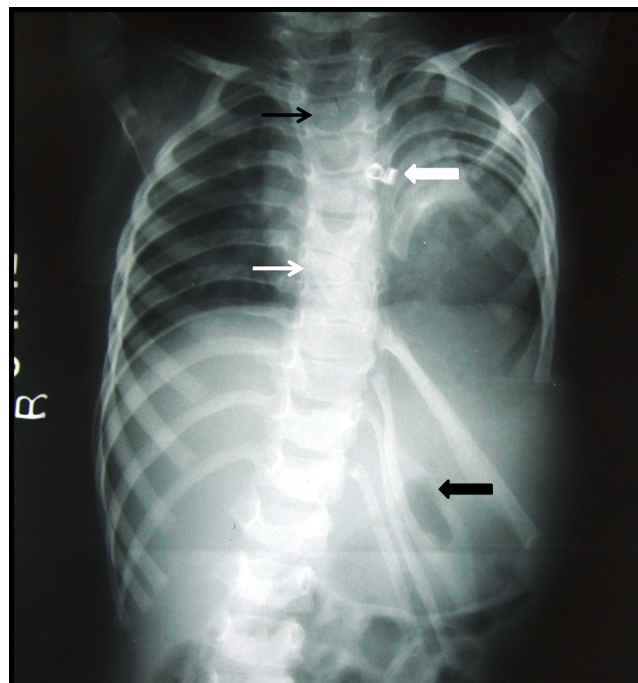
Chest X-ray in posteroanterior view demonstrating scoliosis, hemi-vertebrae (thin white arrow), failure of fusion of the left lower ribs, bifid rib (thick black arrow), spina bifida (thin black arrow) and patent ductus arteriosus coil (thick white arrow) in situ.
